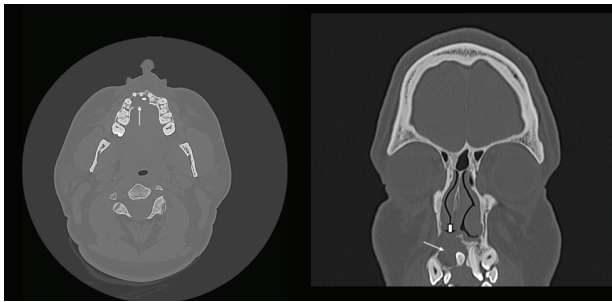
Axial CT image of the head at the level of the maxilla on the left demonstrates a cystic expansile lesion (long thin arrow) near the incisors on the right with mild displacement of adjacent teeth. On the right a coronal CT image of the head at the level of the anterior maxilla again demonstrates the cystic unilocular expansile lesion (thin long arrow) with adjacent bony thinning and remodeling. Note the bony thinning along the floor of the right nasal cavity with encroachment of the lesion into the right nasal cavity inferiorly (short vertical arrow).
